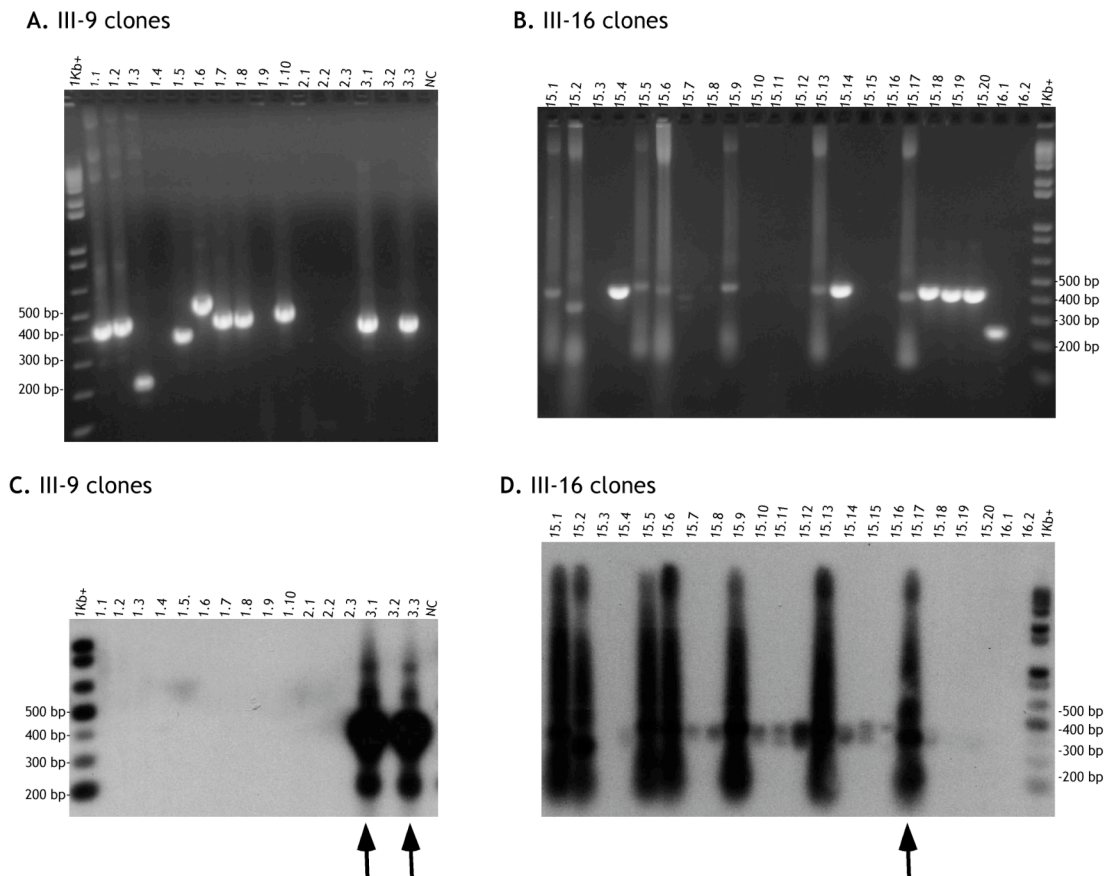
PCR screening of clones. PCR using primers DM-C and TAG4 was performed to evaluate the presence of the insert in the clones obtained. A. Clones obtained from vectorette products generated from III-9 vectorette libraries in A and from III-16 in B. C. and D. Auto-radiographs of gels A. and B. respectively. The arrows indicate the clones selected for sequencing. The sizes of the marker are indicated either on the left or the right side of each panel. NC (negative control).
